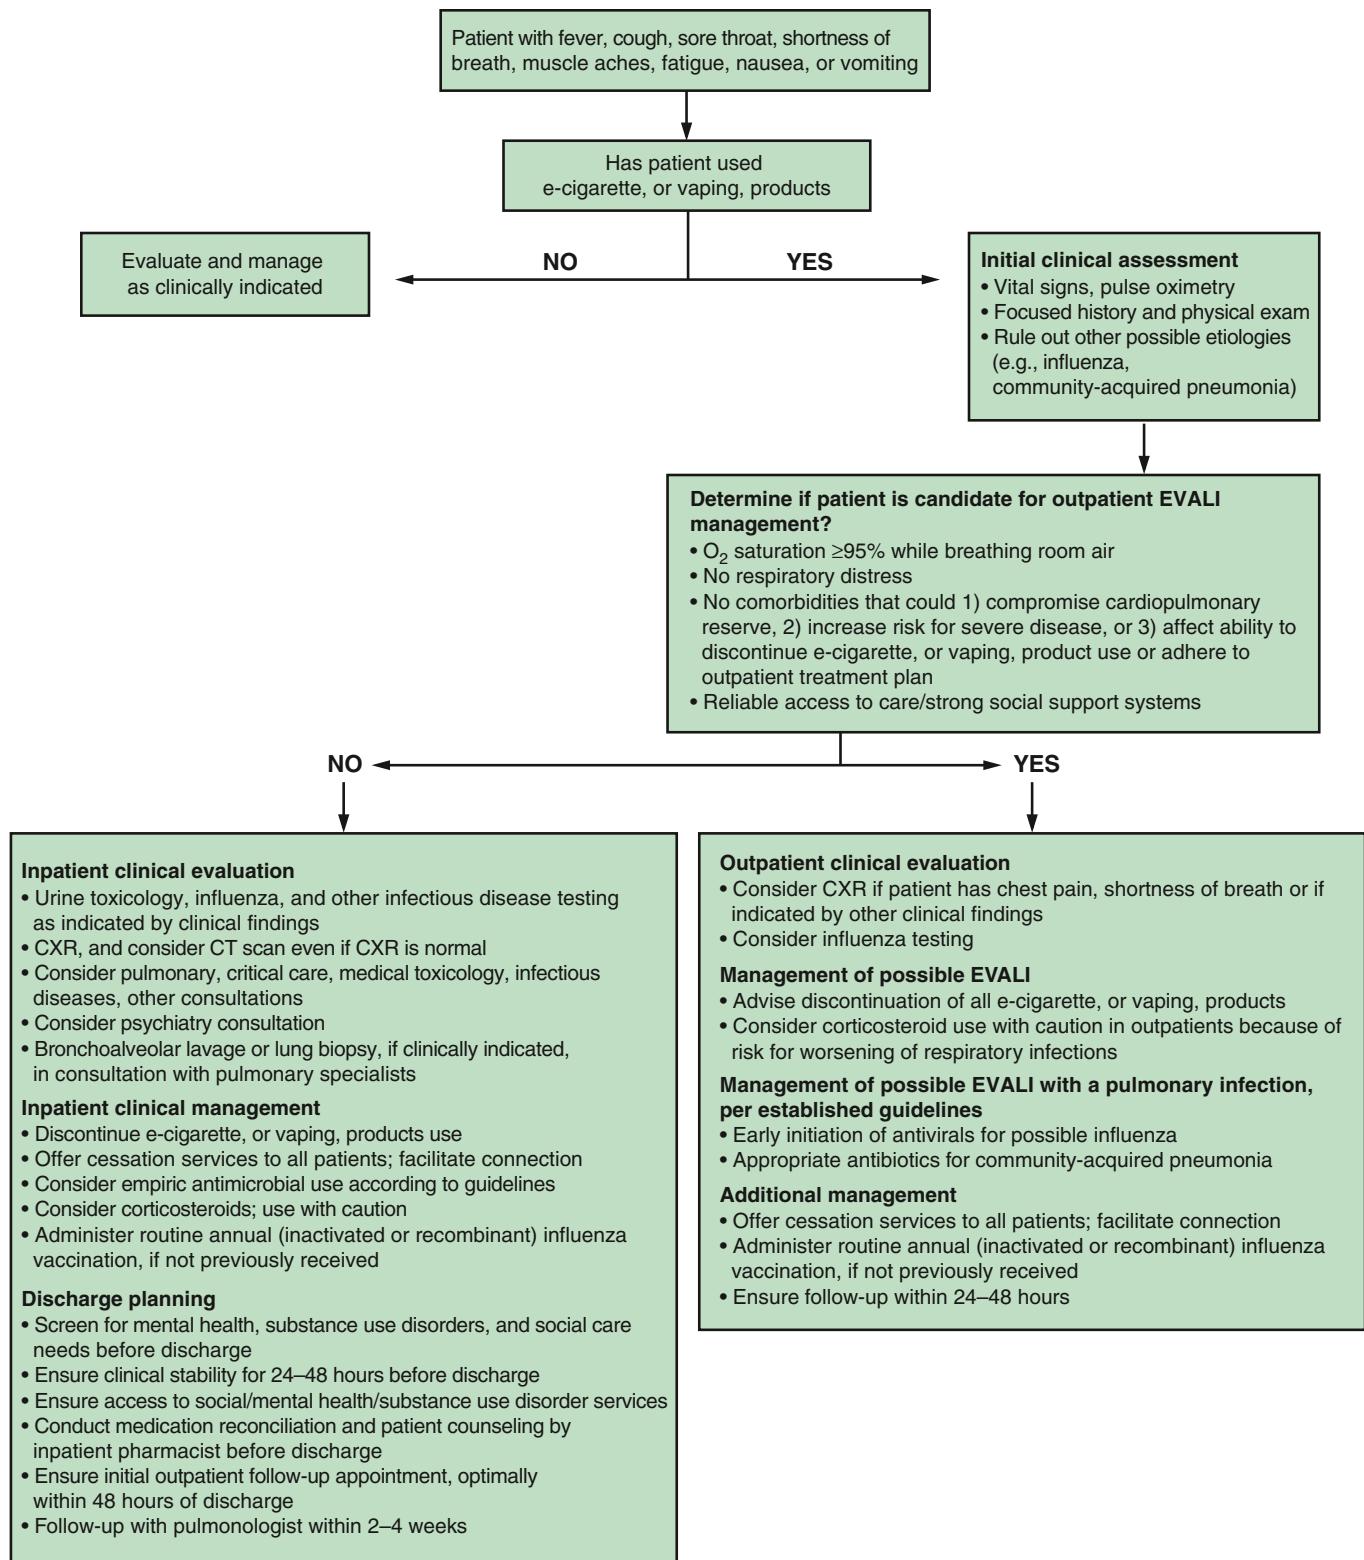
Updated algorithm for management of patients with suspected e-cigarette, or vaping, product use-associated lung injury (EVALI), December 2019. CT, Computed tomography; CXR, chest x-ray.* Influenza vaccination recommendations: https://www.cdc.gov/mmwr/volumes/68/r1/rr6803a1.htm?s_cid=rr6803a1_w. (From Evans ME, Twentyman E, Click ES, et al. Update: interim guidance for health care professionals evaluating and caring for patients with suspected E-cigarette, or vaping, product use-associated lung injury and for reducing the risk of rehospitalization and death following hospital discharge – United States, December 2019. MMWR. 2020;68:1189–1194, Fig. p. 1191.)
